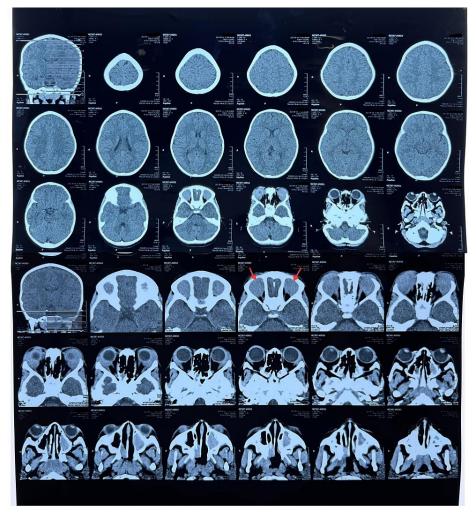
CT Brain Showing Enlarged Lacrimal Glands (Red Arrows)
